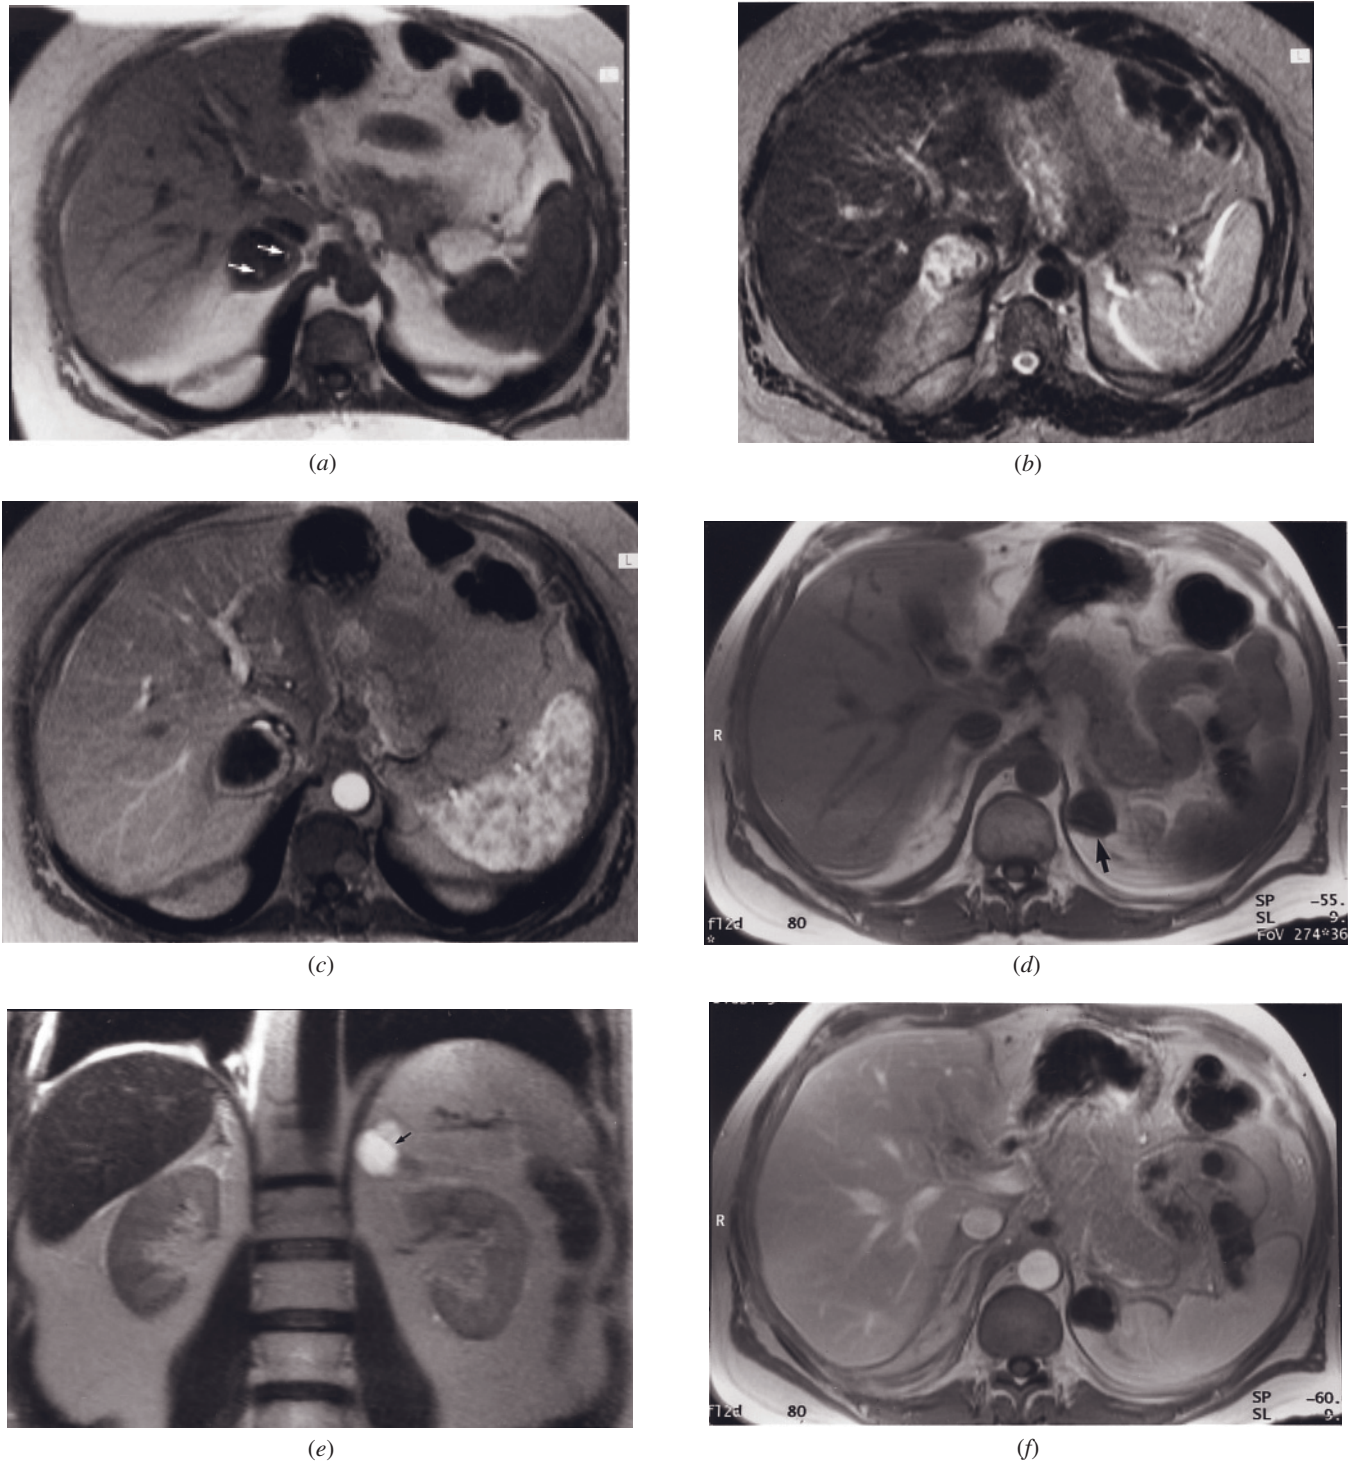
Cyst/pseudocyst. T1-weighted GE (*a*), T2-weighted spin-echo (T2-SE) (*b*), and immediate postgadolinium GE (*c*) images. Small high-signal-intensity foci are noted on the T1 image (arrows, *a*) within the low-signal-intensity pseudocyst, a finding consistent with hemorrhage. The mass is heterogeneous and high in signal intensity on the T2-weighted image (*b*). The heterogeneity reflects the presence of blood products. The lesion is signal void on early (*c*) and late (not shown) postgadolinium images, which are diagnostic features for a cyst. T1-weighted GE (*d*), coronal T2-weighted HASTE (*e*), 45-s postgadolinium GE (*f*), and 90-s postgadolinium fat-suppressed GE (*g*) images in a second patient. An adrenal pseudocyst is identified arising from the left adrenal (arrow, *d*). The pseudocyst is low in signal intensity on the T1-weighted image (*d*) and high in signal intensity on the T2-weighted image (*e*) and does not enhance on early (*f*) or late (*g*) postgadolinium images. Thin septations are present in the pseudocyst
